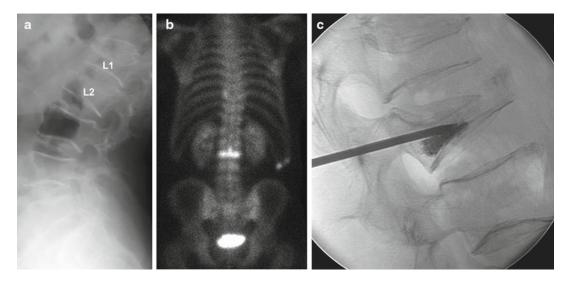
Images of old and recent compression fractures. A 75-year-old man presents with acute upper lumbar pain following minimal trauma. A lateral radiograph (a) shows compression of the bodies of L1 and L2. There were no prior films for comparison. A radionuclide bone
